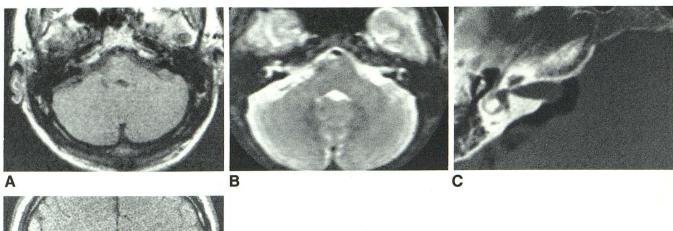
A, T1-weighted axial MR image (850 msec TR, 30 msec TE) was initially interpreted as normal, but some asymmetry was seen retrospectively in cerebellopontine angle cisterns. B, T2-weighted axial MR image (3500 msec TR, 100 msec TE). Minimal asymmetry of internal auditory canals was believed to be normal. C, CT air cisternogram. Small acoustic schwannoma extends minimally into cerebellopontine angle cistern. D, T1-weighted coronal MR image (800 msec TR, 40 msec TE) after cisternogram. Mass (*arrowhead*) in region of right porus acusticus correlates with location of tumor in C and was verified surgically.
